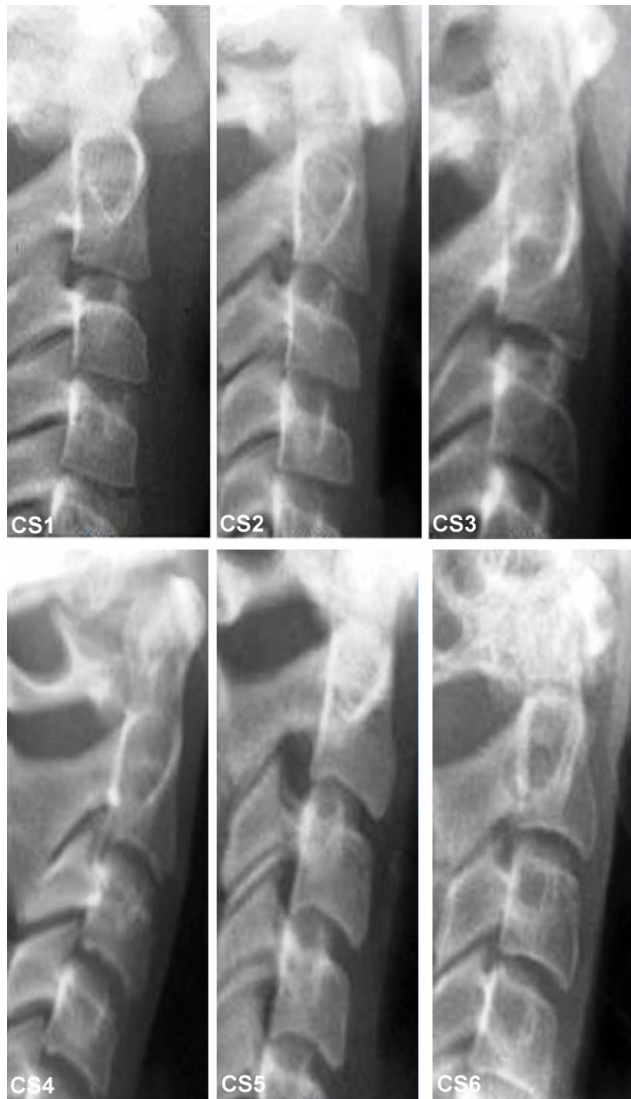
Exemplary lateral radiographic view showing various cervical vertebrae maturation (CVM) stages. (CS – cervical stage) CS (1) – C2-C4 have flat lower margins. C3 and C4 have trapezoid-shaped bodies (the superior margin of the vertebral body is tapered from posterior to anterior). In 2 years, mandibular growth will peak. CS (2) – C2's lower edge is concave (in four of five cases, with the remaining subjects still showing a cervical stage 1). C3 and C4 have trapezoid-shaped bodies. After 1- year, mandibular growth peaks; CS (3) – C2 and C3 have lower concavities. C3 and C4 have trapezoid or horizontal rectangular bodies. After one year of this stage, mandibular growth peaks; CS (4) – Lower margins of C2, C3, and C4 now have concavities. C3 and C4 have horizontal rectangular bodies. 1 or 2 years before this stage, mandibular growth peaked; CS (5) – Lower margins of C2, C3, and C4 have concavities. At least one of C3 and C4 have square bodies. The other cervical vertebra is rectangular if not squared. Mandibular growth peak ended 1 year earlier; CS (6) – Lower C2, C3, and C4 still have concavities. At least one of C3 and C4 have rectangular vertical bodies. If not rectangular vertical, the other cervical vertebra is square. Mandibular growth peaked 2 years earlier.
